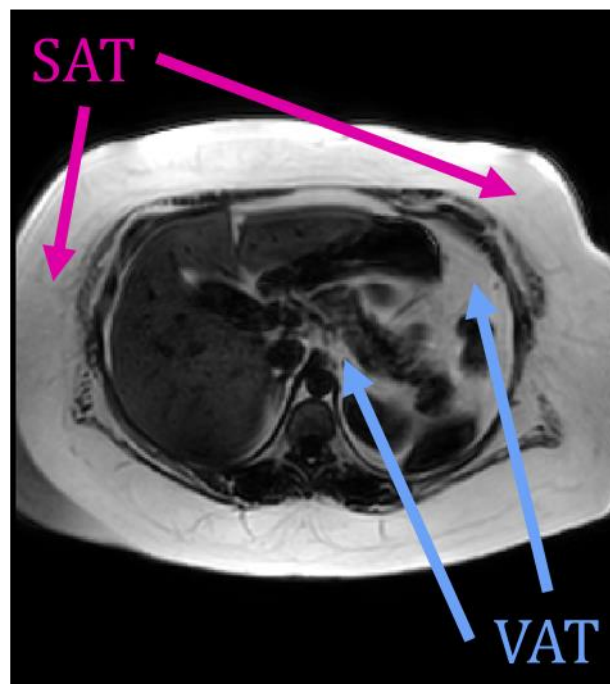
Cross-sectional MRI of the body showing stored Subcutaneous Adipose Tissue (SAT) and Visceral Adipose Tissue (VAT)
